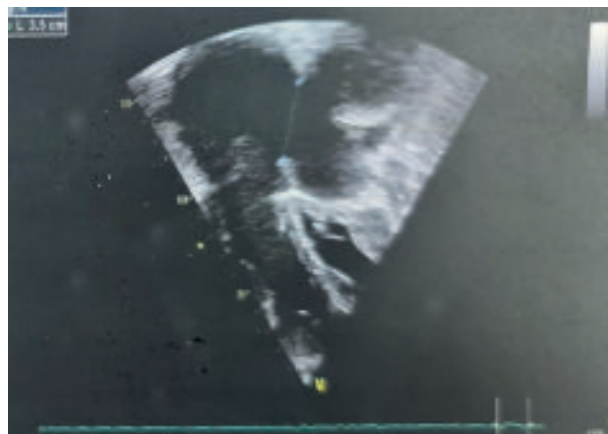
Transthoracic Echocardiography (Apical 4C view) showing atrial septal defect and mitral stenosis.
